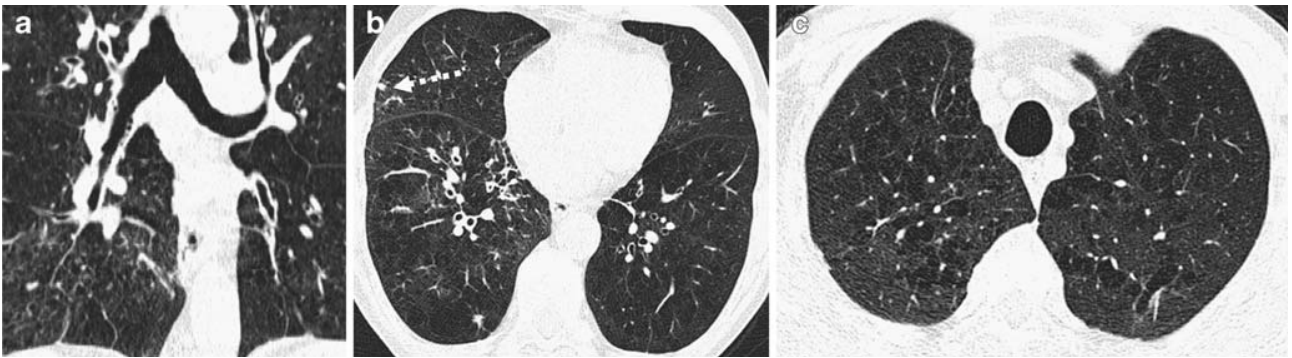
A 62-year-old male smoker with a history of coughing. (a) Coronal reformatted thin-section CT image shows multiple tubular, air-filled structures (arrows) arising from the walls of the bronchus intermedius, scored as grade 2 bronchial diverticula. (b) Axial image shows coexisting bronchial wall thickening that was scored as grade 2 and 1 at the level of the right and left lower lobes respectively by both radiologists; mild mucus plugging is also evident at the periphery of the middle lobe (arrow). (c) Moderate emphysema was also present within the upper lobes.
